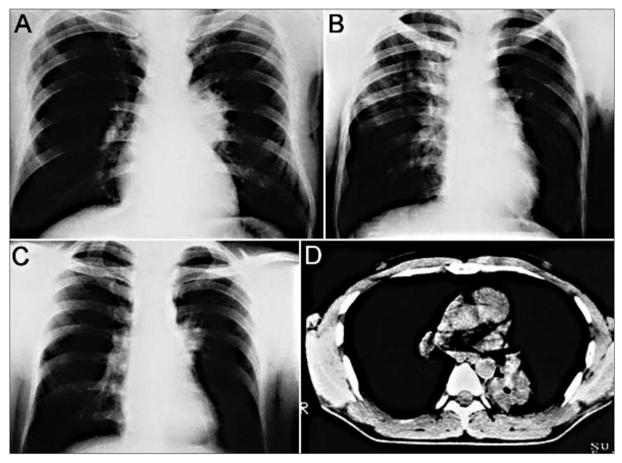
The radiological findings of three atypical pulmonary hydatid disease cases. (A-C) Chest radiographs of cases 1 and 3 showing left hilar mass lesions resembling malignant tumors, respectively. (B) Chest radiograph of case 2 demonstrating heterogeneous paranchymal infiltration with air bronchograms in right paratracheal zone suggestive of pulmonary tuberculosis or pneumonia. (D) Chest CT of case 3 showing cavitary solid tissue lesion with perifocal consolidation signifying bronchogenic carcinoma.
